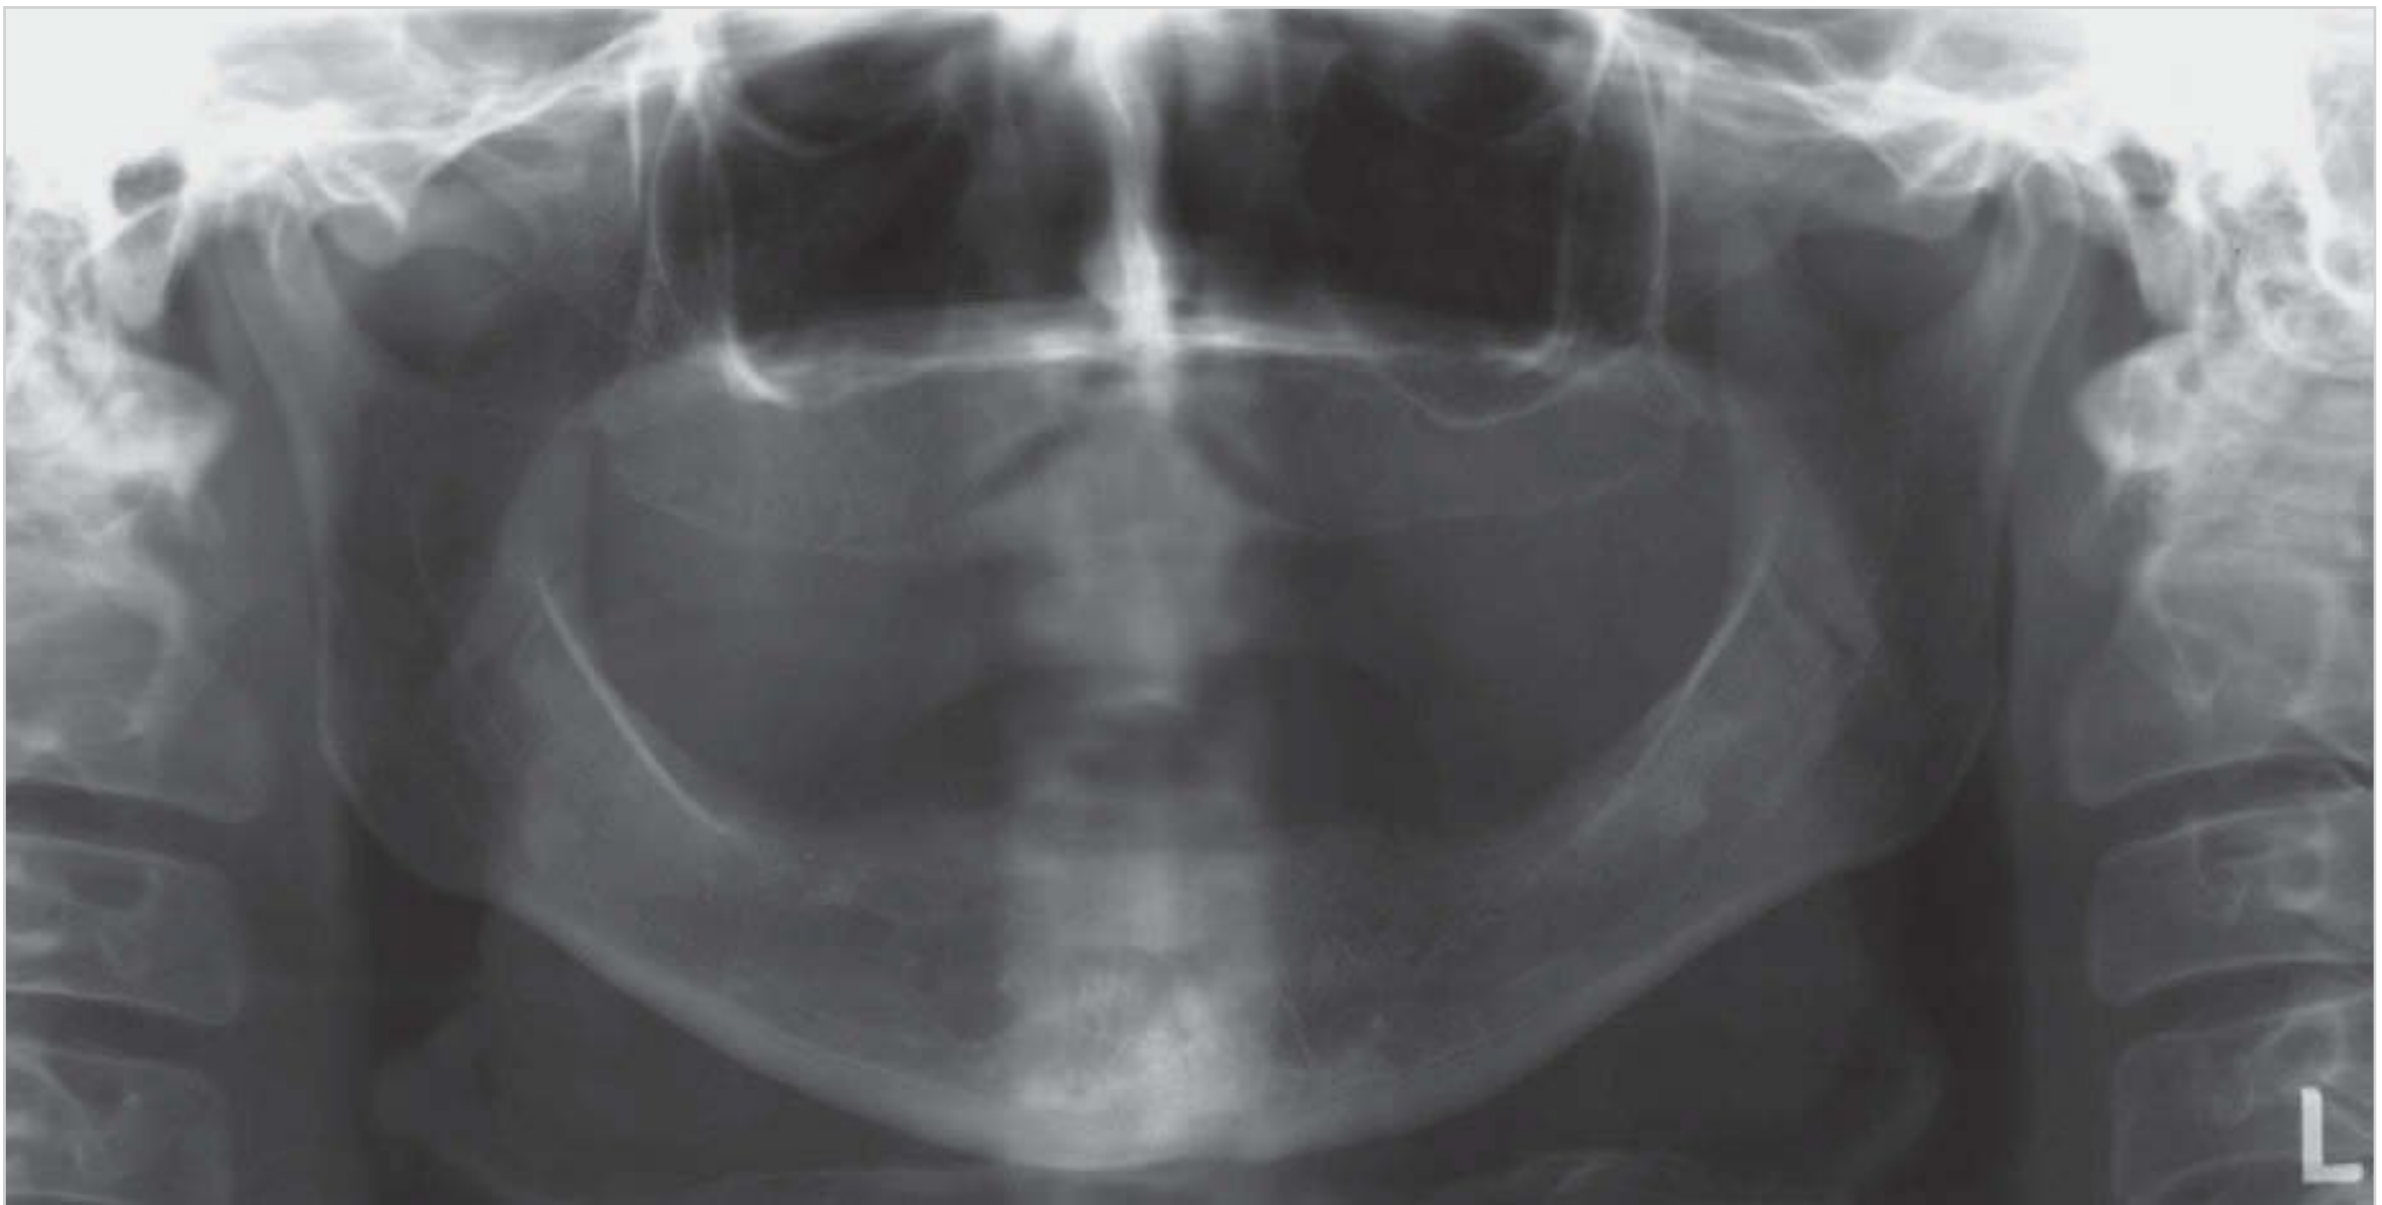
Panoramic radiograph showing ghost images of the cervical spine, projected three times.
